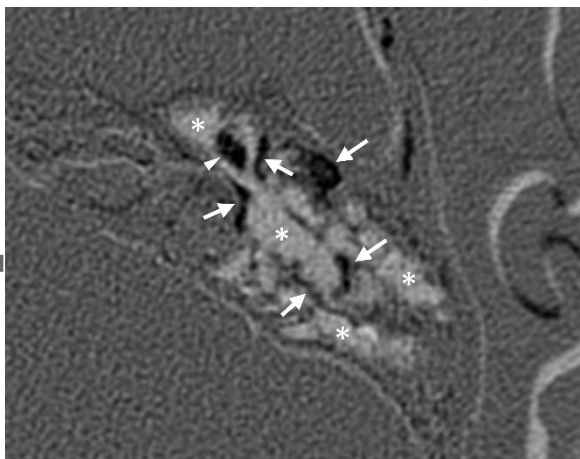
46-year-old female with a cholesteatoma of the left middle ear. The temporal subtraction CT was obtained by subtracting the remote high-resolution CT (HRCT) from the preoperative HRCT. The temporal subtraction CT shows the mastoid cell wall (arrows) and ossicles (arrowhead) in black color, indicating progressive bone erosive changes. The black color in the mastoid region indicates the presence of mastoid extension of the middle ear cholesteatoma. Other areas within the tympanic cavity and mastoid are shown in white color (*), indicating increased non-specific inflammatory changes. Surgery revealed mastoid extension.
